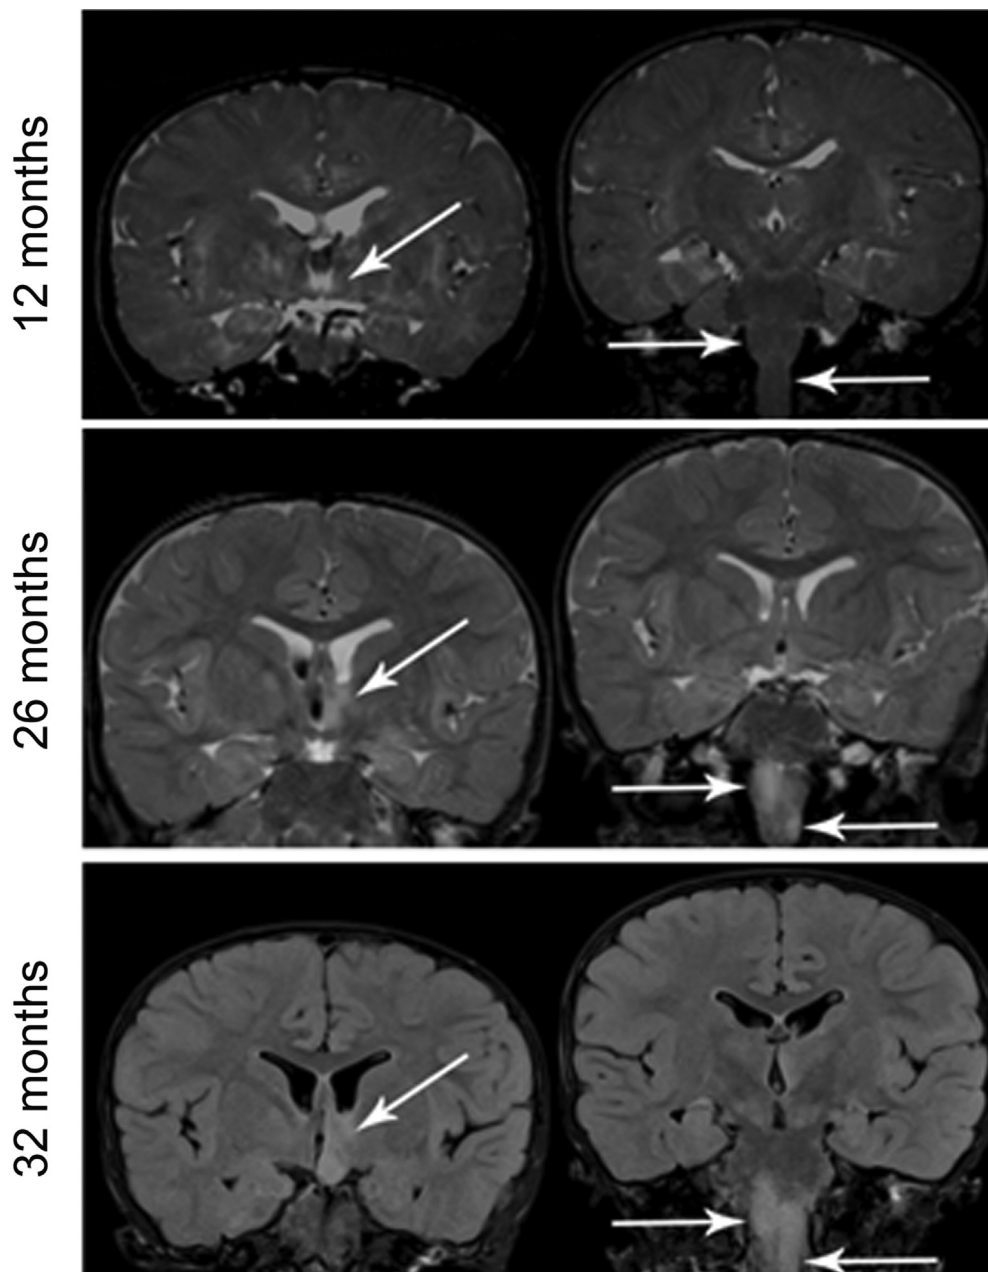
Neuroimaging reveals the de novo development of a hypothalamic glioma. Coronal reconstructions of serial brain MRI scans at 12 (T2-weighted), 26 (T2-weighted), and 32 (fluid-attenuated inversion recovery; FLAIR) months of age, demonstrating the development of multifocal gliomas beginning at 26 months in regions previously appearing normal at 12 months (arrows).
